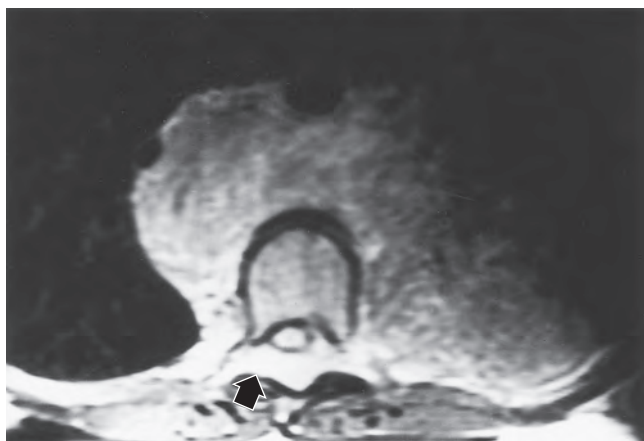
Magnetic resonance image of child with thoracic ganglioneuroma extending into the spinal canal (arrow).
